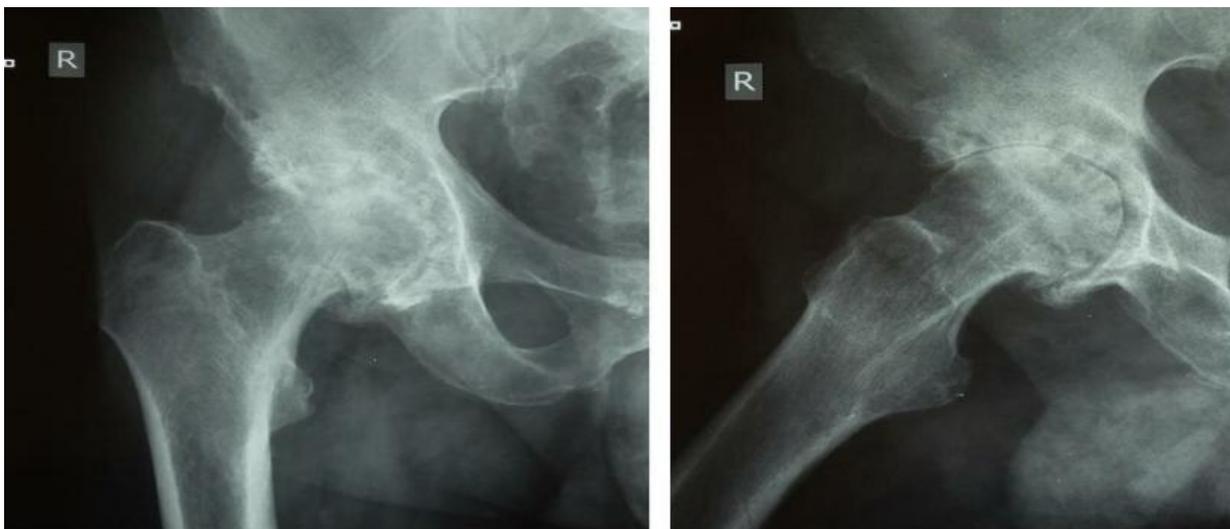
X-ray of patient M.A., 1982, No. IB 5185/543, with stage 3 of the disease ANFH.
